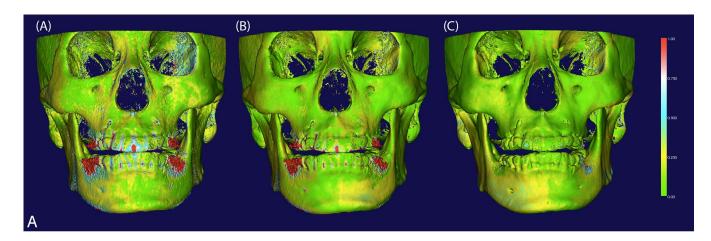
Different kVp settings with other settings fixed at 10 mA and 300 μ m. (A) Color-coded maps showing superimposed CBCTs with different kVp settings: (A) 60 vs 90 kVp; (B) 70 vs 90 kVp; and (C) 80 vs 90 kVp. (B) Graphic showing different kVp settings compared to model-to-model distance. The closer the models, the more accurate is the superimposition. CBCT indicates cone beam computed tomography; kVp, kilovolt peak.
